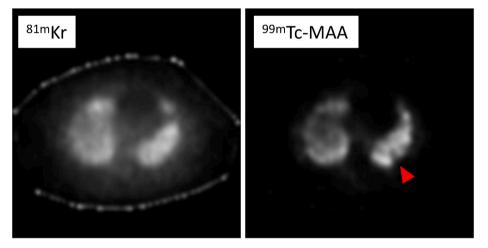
Pulmonary perfusion-ventilation scintigraphy.
